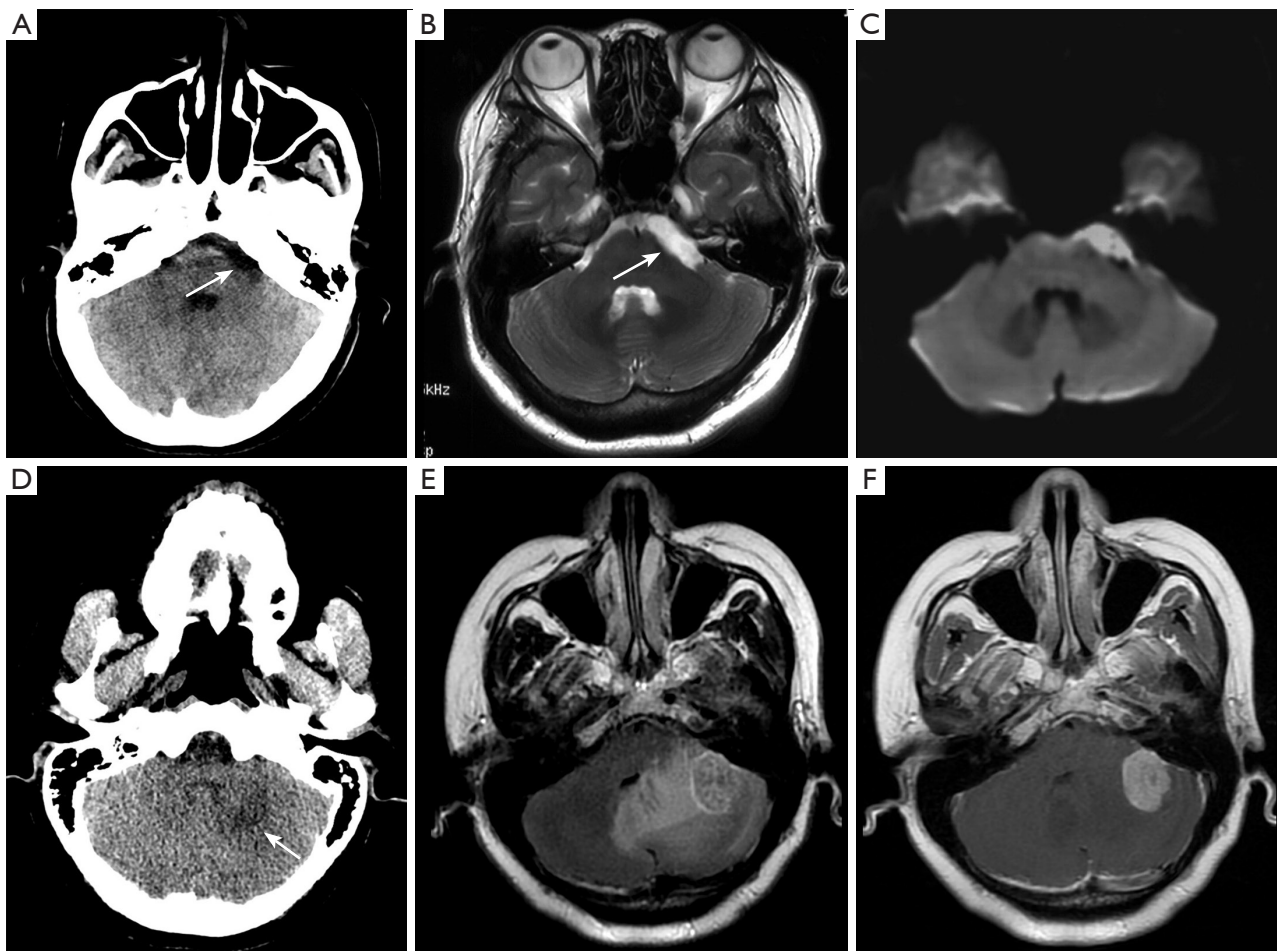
Blind spot in brain imaging: posterior fossa. (A-C) Scans of a 34-year-old female who had experienced left facial pain for one year. (A) CT images revealed a low-density lesion (arrow) in the anterior aspect of the brainstem, extending into the left pontocerebellar angle region. (B,C) In the brain MRI examination, the lesion displayed high signal intensity on T₂WI/FLAIR (arrow) (B) with restricted diffusion on DWI (C). Finally, postoperative pathology confirmed the diagnosis of an epidermoid cyst. (D-F) Scans of a 53-year-old female with lymph node metastasis who had undergone surgery for right breast cancer, and 2 months of postoperative chemotherapy. (D) Radiologists overlooked a low-density lesion in the left cerebellum (arrow) in the neck and chest CT scan, (E,F) which was later shown to be a metastatic tumor by MRI. Neck CT scans can include the posterior fossa; however, this crucial region tends to be disregarded by radiologists. Therefore, importance should be attached to this area in image interpretation. CT, computed tomography; MRI, magnetic resonance imaging; T₂WI/FLAIR, T2-weighted image/fluid-attenuated inversion recovery; DWI, diffusion-weighted imaging.
